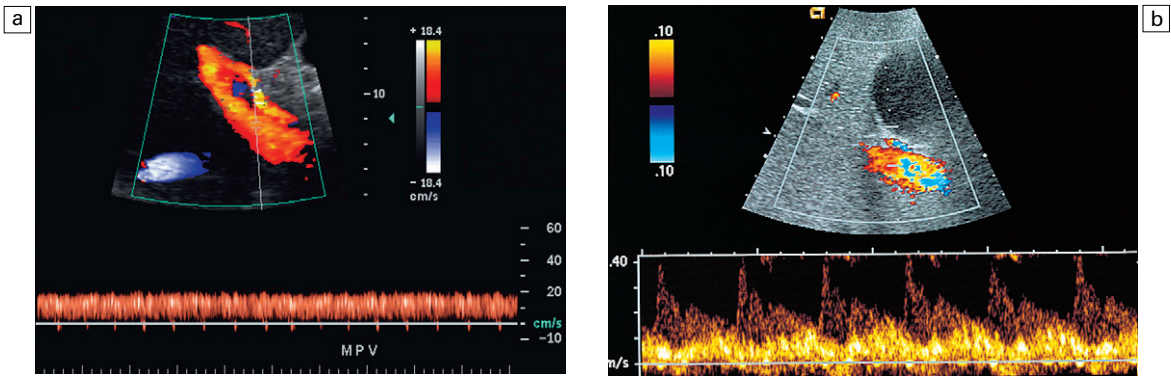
(a) Spectral Doppler tracing of normal portal vein flow. The flow velocity of 20 cm s^{-1} is relatively uniform and in a hepatopetal direction. (b) Spectral Doppler tracing of a normal portal vein flow. Slight periodicity is present in this patient's portal vein tracing. The dip in antegrade velocity coincides with hepatic arterial systole. Velocity variation may also occur due to pressure change with the hepatic vein A-wave.
